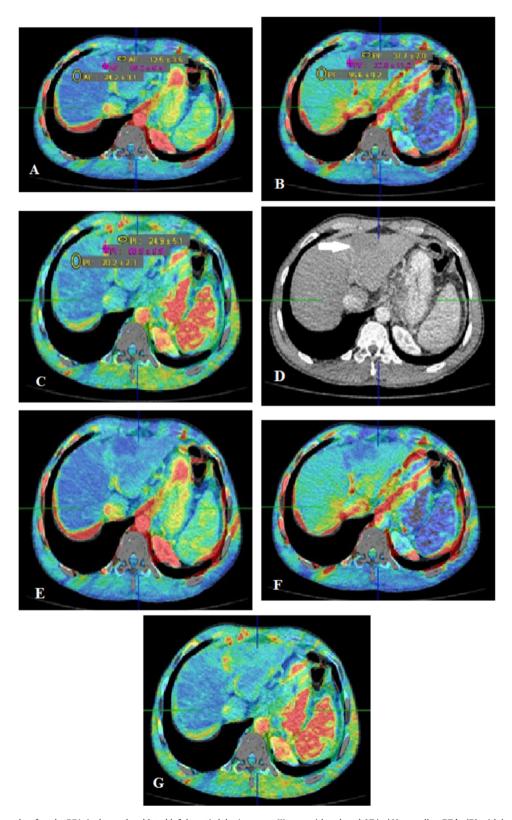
CTP is done 6 months after the RFA. It shows the ablated left hepatic lobe (segment II) area with reduced AF in (A) as well as PF in (B) with low PI in (C) in relation to the surrounding hepatic parenchyma; (D-F): same images without the perfusion parameters showing the poorly perfused left hepatic lobe area after the RFA; (D) the hepatic CT density (white arrow), (E) AF, (F) PF and (G) PI in color mapped images. Diagnosis: post RFA for left hepatic lobe HCC with no active tumoral tissues or recurrent lesions.
